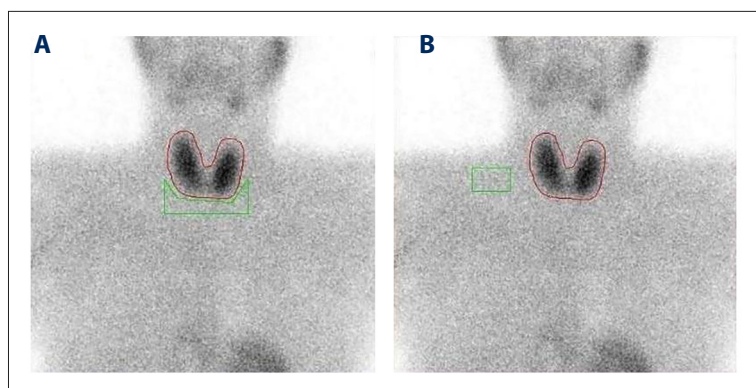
^{99m}Tc -Methoxy-2-Isobutylisonitrile (MIBI) thyroid scintigraphy at 10 min post-injection, anterior projection (early images). Thyroid and mediastinal regions of interest (A), thyroid and supraclavicular regions of interest (B).
